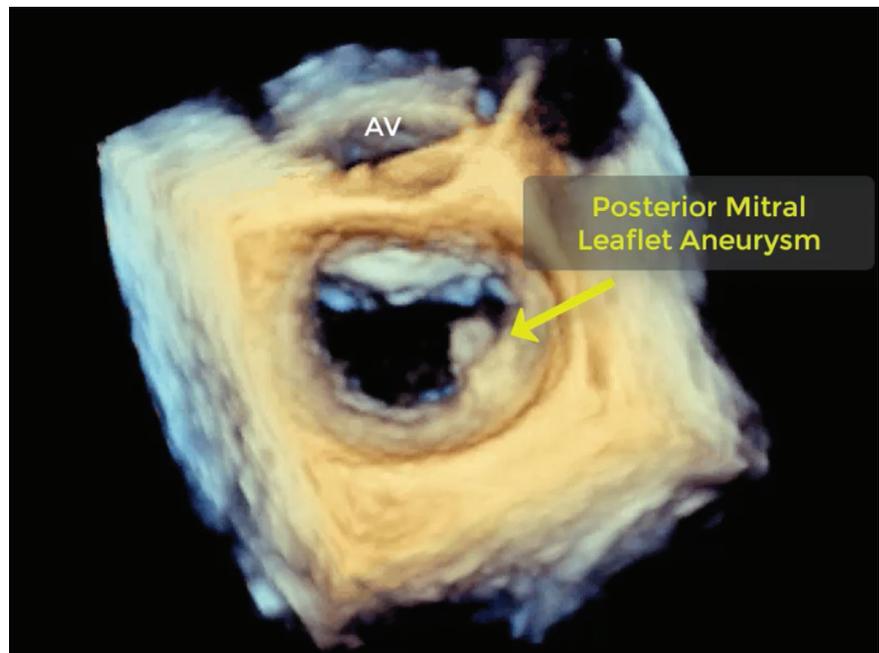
3D Transesophageal echocardiogram. The so-called surgical view of the mitral valve demonstrates posterior mitral leaflet aneurysm of P2 and P3 scallops (Panel A) resulting in severe eccentric mitral regurgitation (MR) through aneurysm perforation (Panel B). AV, aortic valve; LAA, left atrial appendage. Video 3 corresponds to this figure
